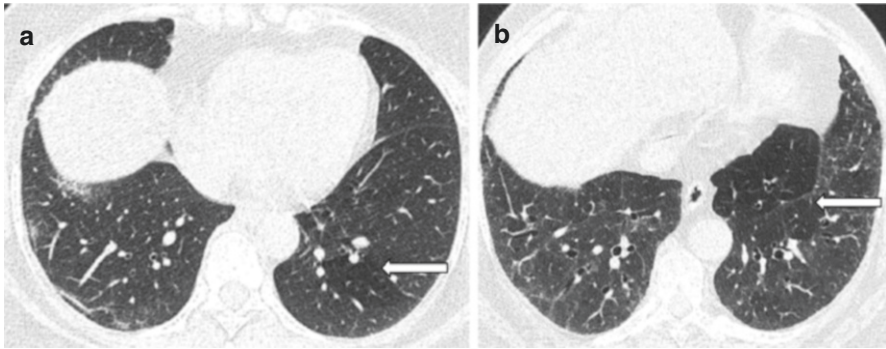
(a, b) HRCT images of two patients of COVID-19 pneumonia demonstrating areas of low attenuation (arrow) mixed with areas of surrounding high attenuation (mosaic attenuation)
